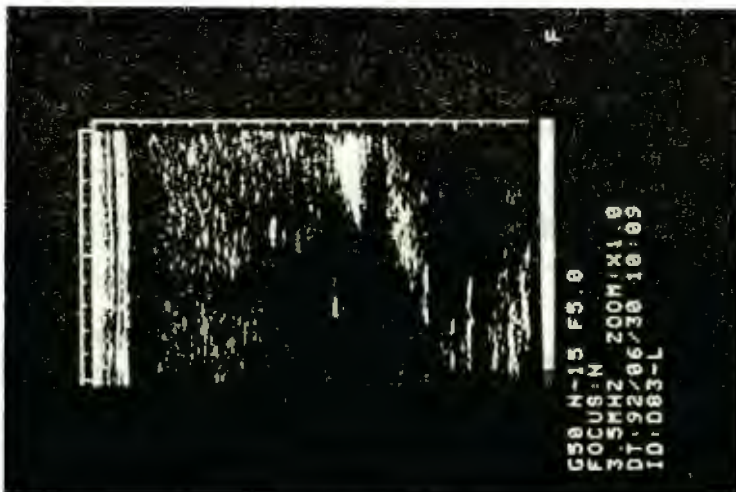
Ultrasongram of severe hydropic degeneration of the liver.
